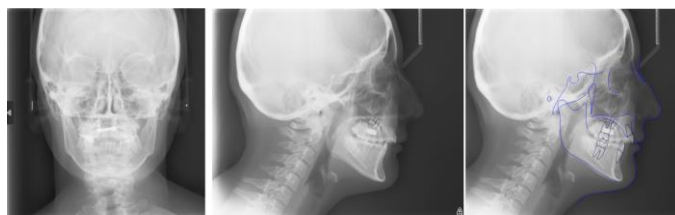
Cephalometric radiographs at the end of consolidation
